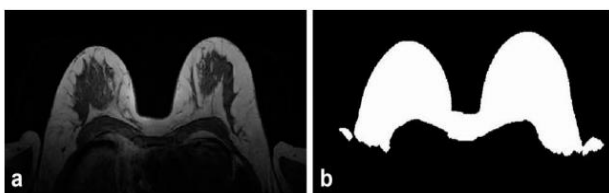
Sample input image of MRI
